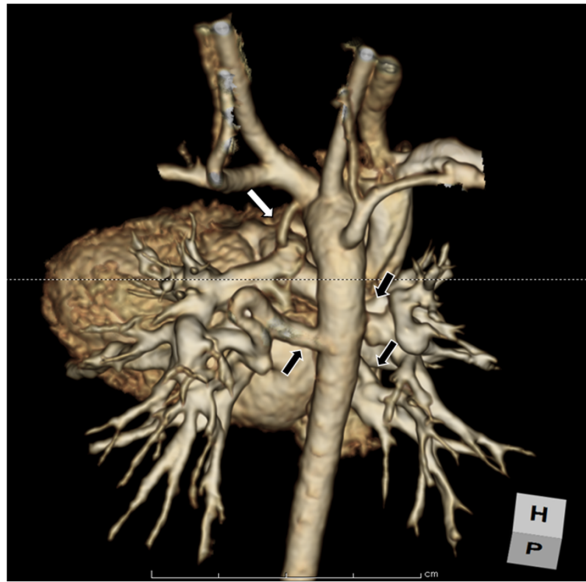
Contrast enhanced computed tomography image, showing 3 MAPCAs (black arrows) and a small vessel which appear to be a remnant of the patent ductus arteriosus (white arrow). MAPCA, major aortopulmonary collateral arteries
